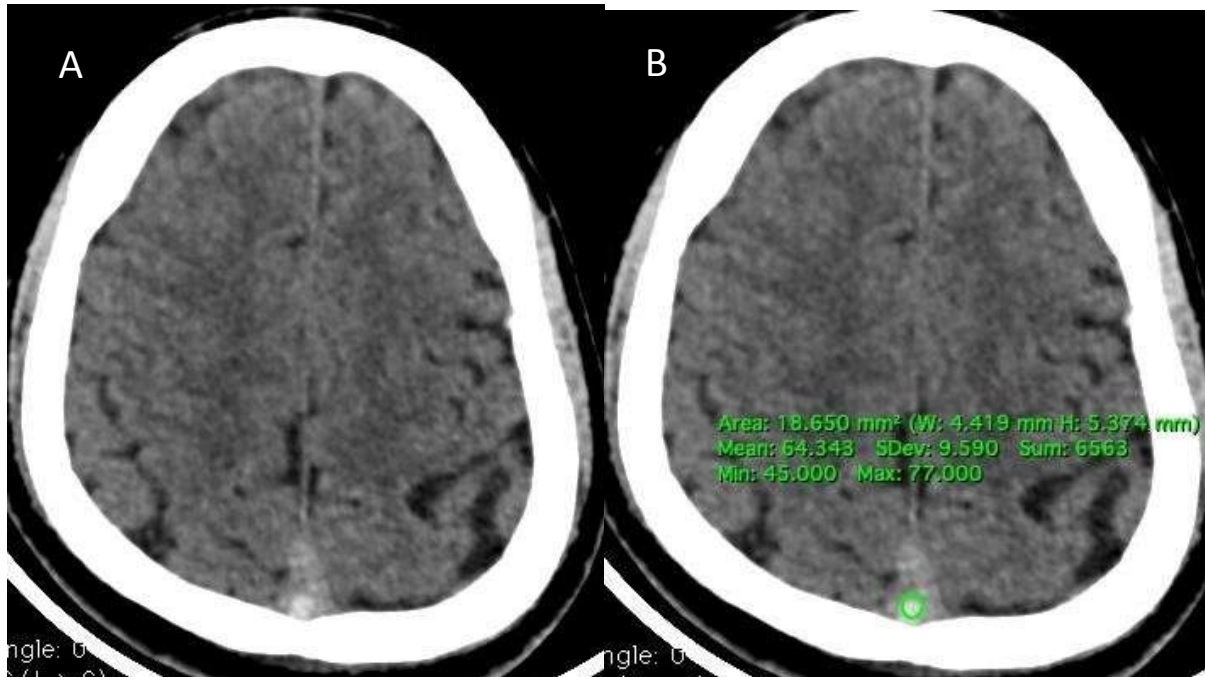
axial section of CT brain showing dense SSS (A) with HU of 64 (B) and CE venography showing corresponding filling defect in SSS (C) / thrombosis.
